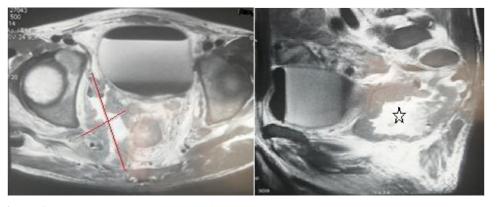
Pelvic MRI showing a large, irregular pararectal mass measuring 77x98x107 mm.
